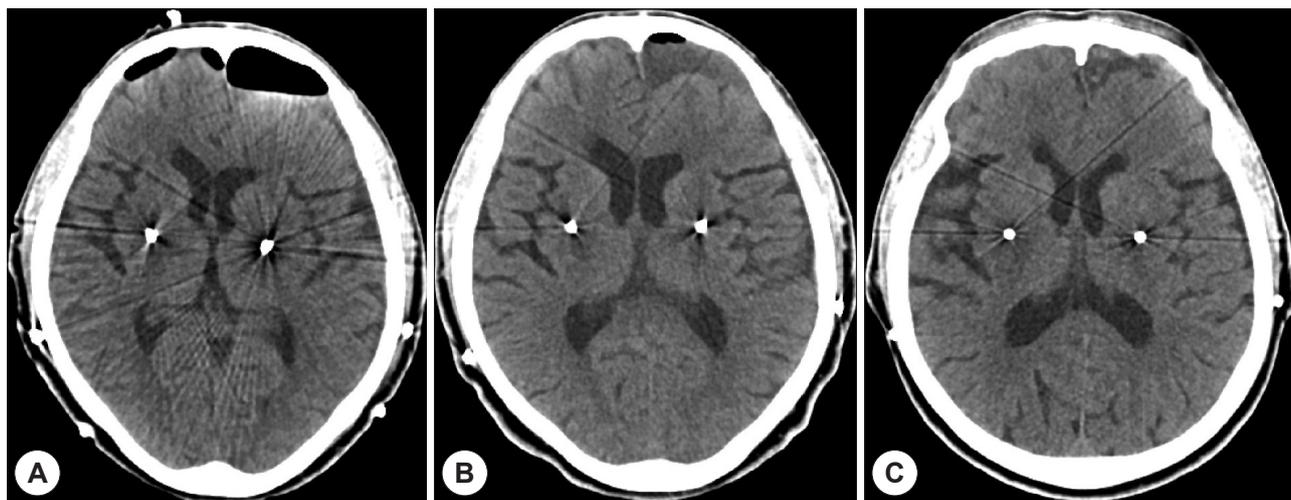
A : Post-operative CT scan after bilateral burr-hole drainage. B : CT scan on 7th postoperative day. C : Follow up CT scan after 2 month from the bilateral burr-hole drainage shows resolving subdural hematoma. Also, the electrode displacement resolves with resolution of the hematoma.
